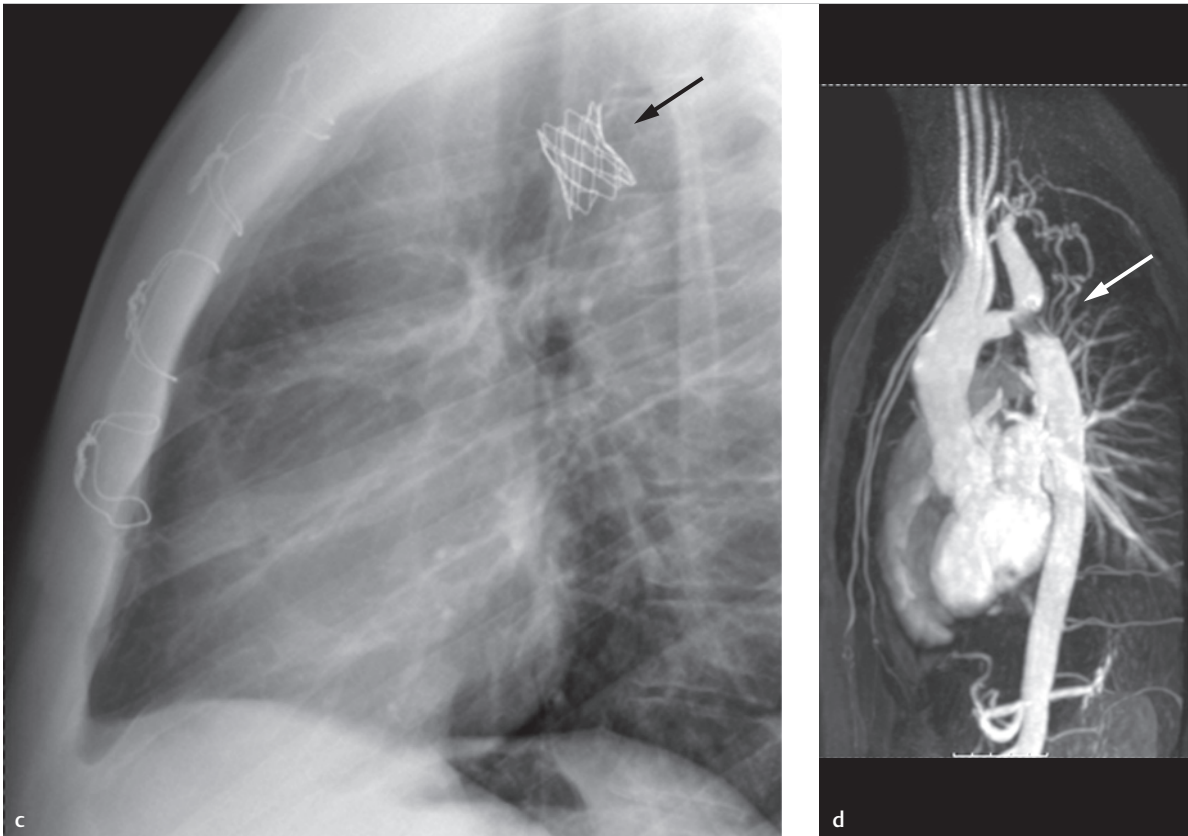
(Continued) Combination of ultrasound, X-ray, and angiography. Diagnosing and treating recoarctation via stent implant.
